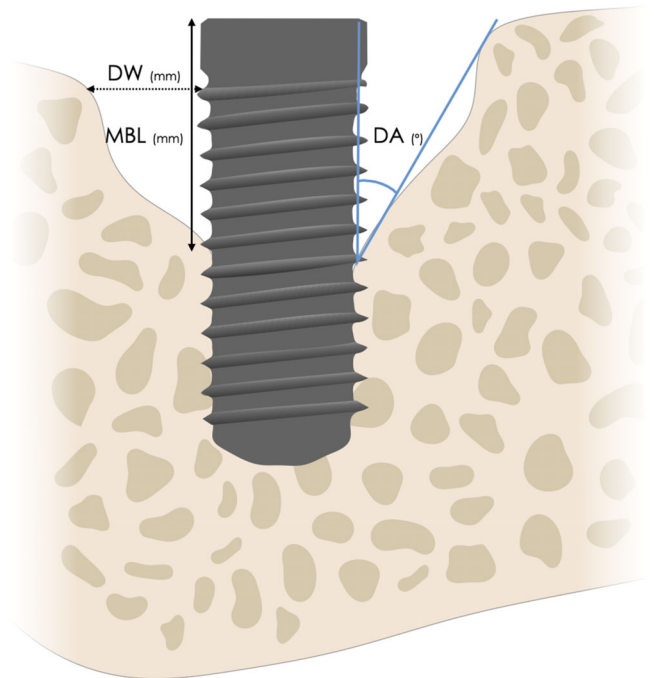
Radiographic morphological variables analyzed. DA, defect angle; DW, defect width; MBL, marginal bone loss.
